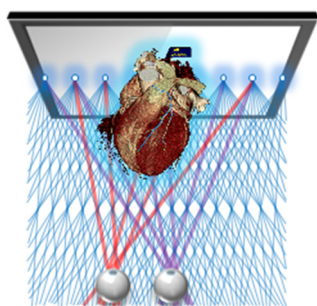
3D cardiac CT navigator concept.
